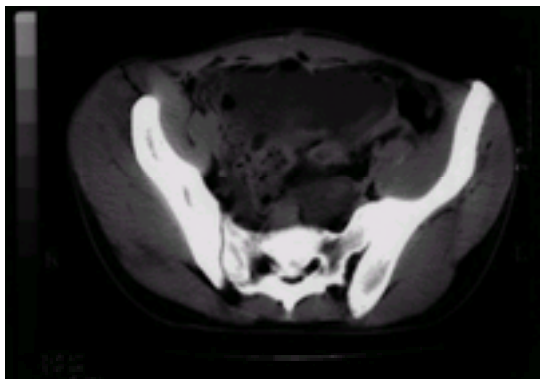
CT demonstrating an intra-abdominal abscess.
